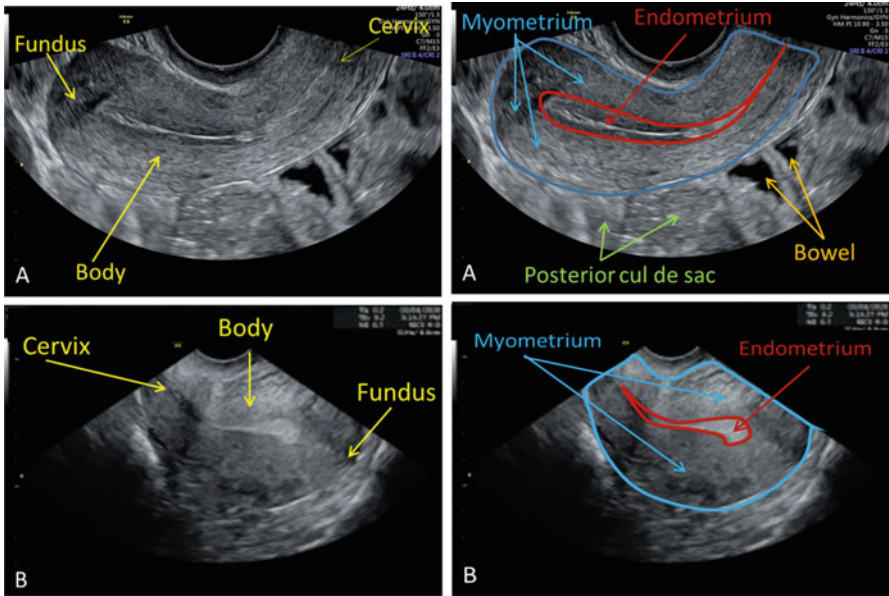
Ultrasound of normal uterus in the longitudinal plane using endovaginal transducer placement. The normal uterus during female reproductive years is pear shaped and has a body twice the size of the cervix. The outer contour is flat or slightly convex and the inner endometrial cavity contour is flat. The top panels (A) show an anteverted uterus (angles anterior), while bottom panels (B) show a retroverted uterus (angles posterior)
